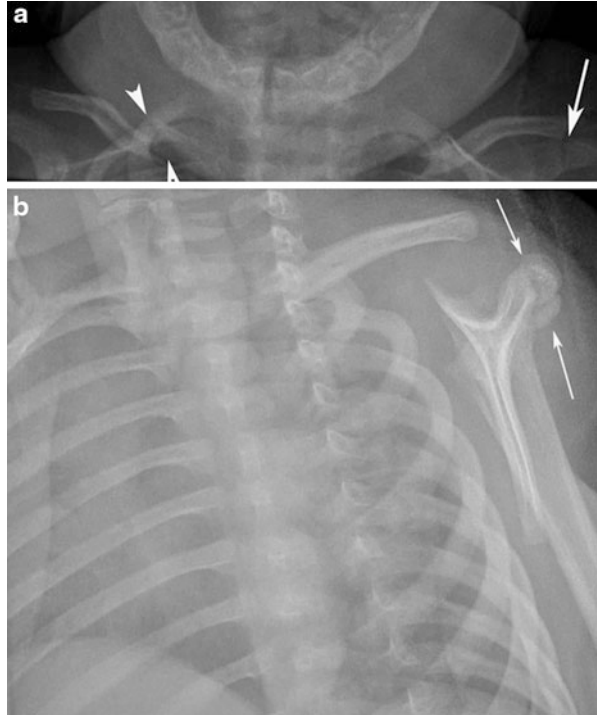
(a): Frontal radiograph in a 1-month-old female with non accidental trauma showing an acute transverse nondisplaced fracture in the acromion process of left scapula seen as a vertical lucency (*arrow*). Acute right clavicle fracture can also be seen with displacement (*arrowheads*). (b): Follow-up oblique view radiograph done 2 weeks after the initial skeletal survey shows callus formation in the acromion process of left scapula (*arrows*)
